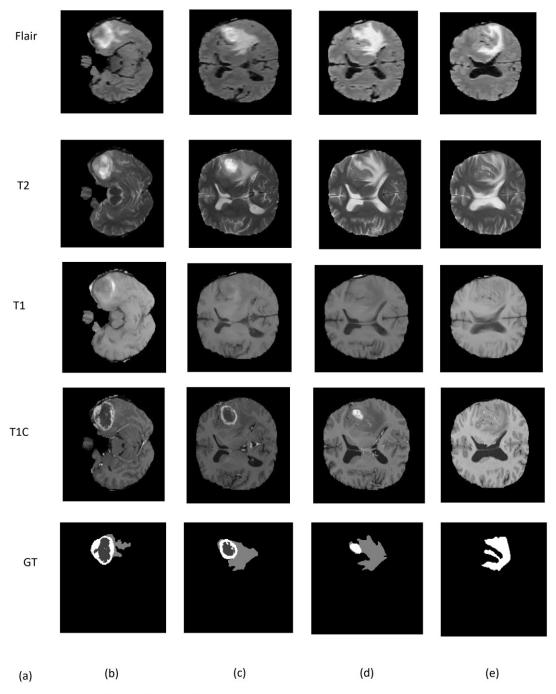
3: Slices of brain MR image taken from the BRATS 2013 dataset. a. modality, b. slice70, c. slice95, d. slice102, e. slice109
